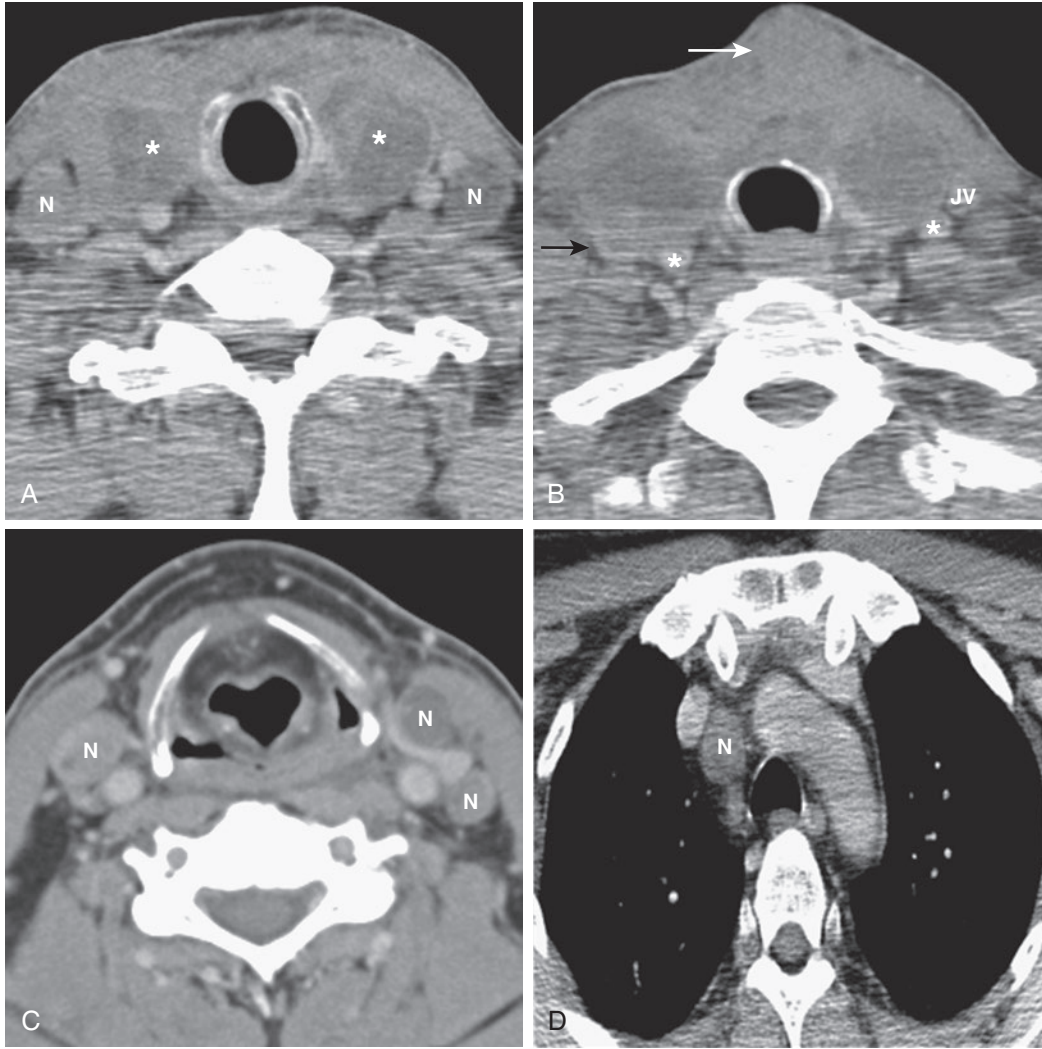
Anaplastic thyroid cancer on contrast-enhanced CT.
